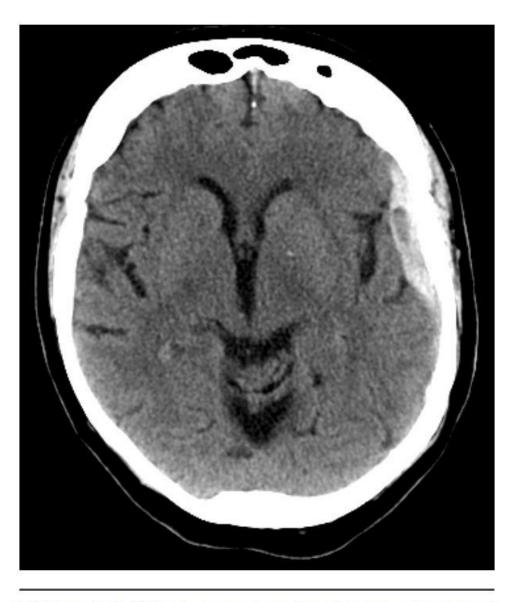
What do you notice that is abnormal in this CT scan?
